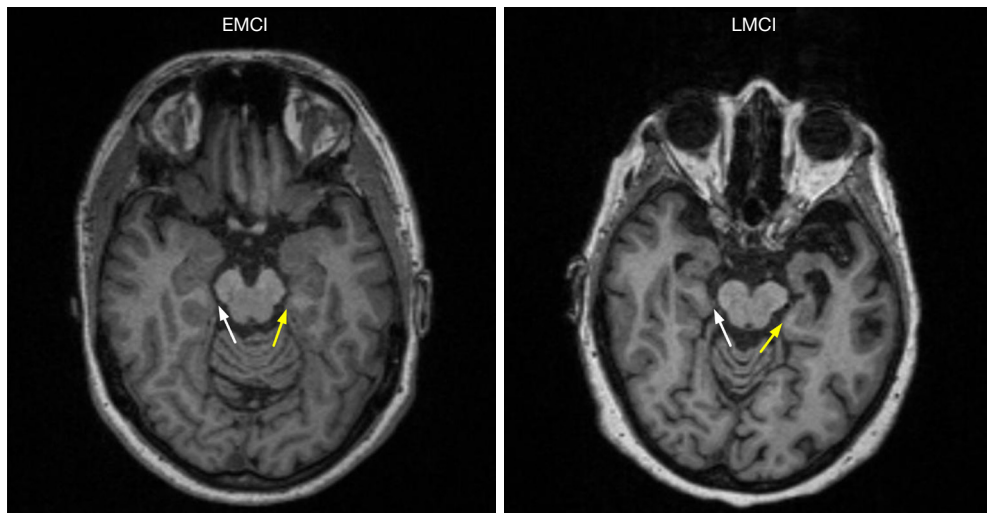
Typical structural head MRI from EMCI and LMCI individuals displaying thickness of bilateral entorhinal. LMCI individual had smaller thickness of bilateral entorhinal. White arrow indicates right entorhinal. Yellow arrow indicates left entorhinal. EMCI, early mild cognitive impairment; LMCI, late mild cognitive impairment.
